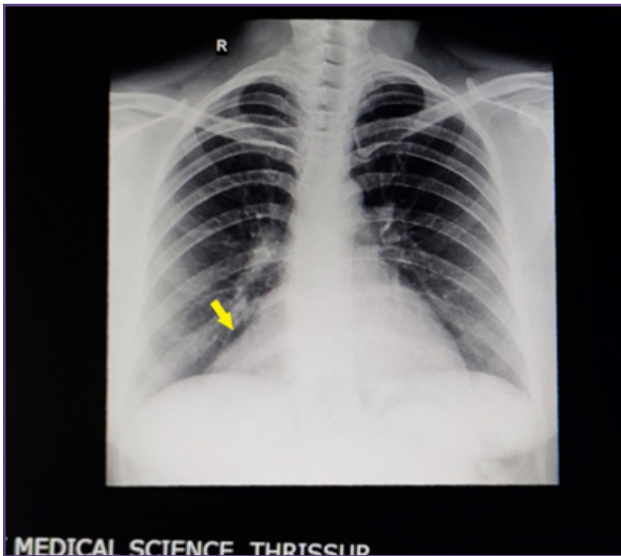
Chest X-ray revealed a homogenous opacity (yellow arrow) at the right cardiophrenic recess.
